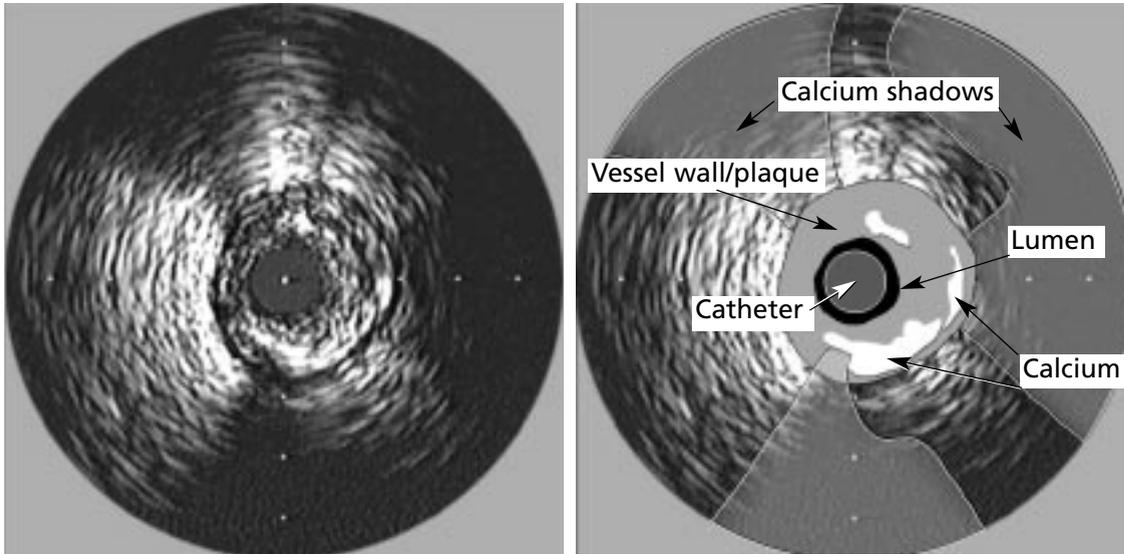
Intravascular ultrasound image of a highly stenotic, calcified coronary lesion.
